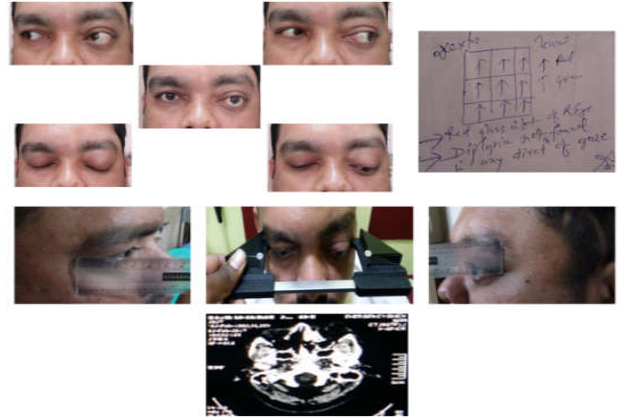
seven months post-op with no diplopia and CT showing few fibrodysplastic growth
